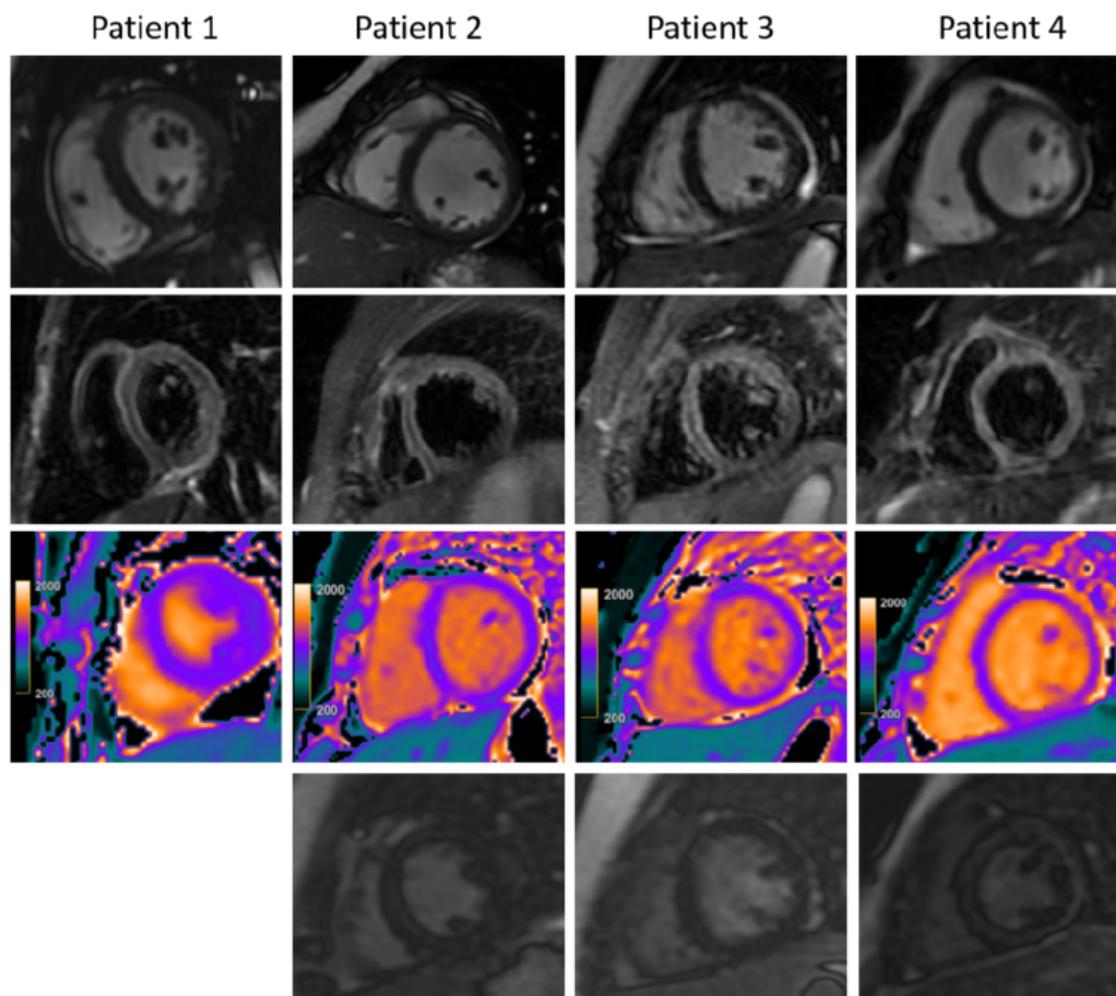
Cardiac MRI for four children with clinical diagnosis of acute myocarditis in the setting of COVID-19–related Kawasaki-like symptoms. The top panel demonstrates minimal pericardial effusion on cine images. The second panel demonstrates increased T2-STIR signal intensity with average ratios between myocardium and muscle > 2 in patient 2 (12-year-old male), patient 3 (11-year-old female) and patient 4 (6-year-old female). The third panel demonstrates abnormal native-T1 mapping, which was > 1100 ms in patients 2, 3 and 4 and normal in patient 1 (8-year-old female). The bottom panel demonstrates absence of late gadolinium enhancement (LGE) in patients 2 and 3. Myocardial null times were recognized as too short in patient 4 but could not be repeated due to lack of further patient cooperation; however review of Look Locker images and additional sequences revealed no LGE.
